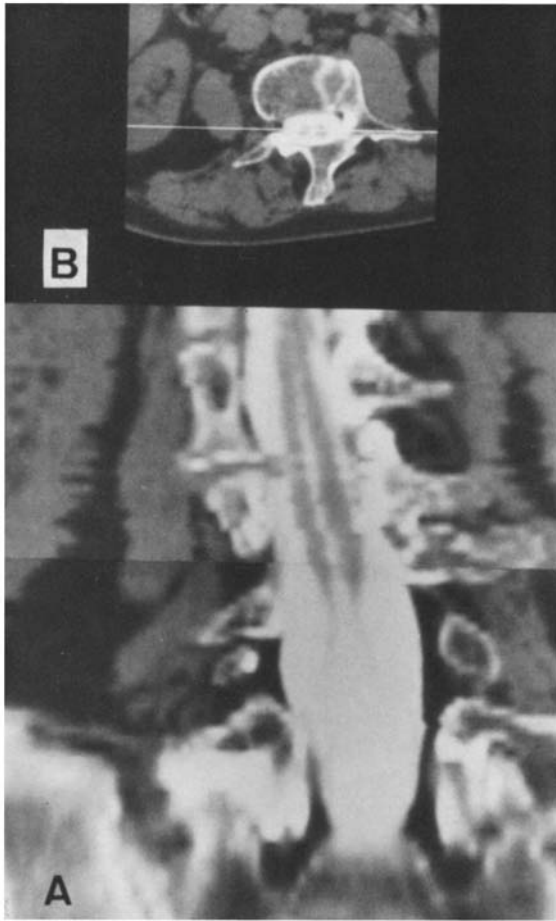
CT myelography, image reconstruction in the frontal plane (A), the longitudinal splitting of the spinal cord is visualized in its whole extension. The orientation of the calculated image is shown in (B)
